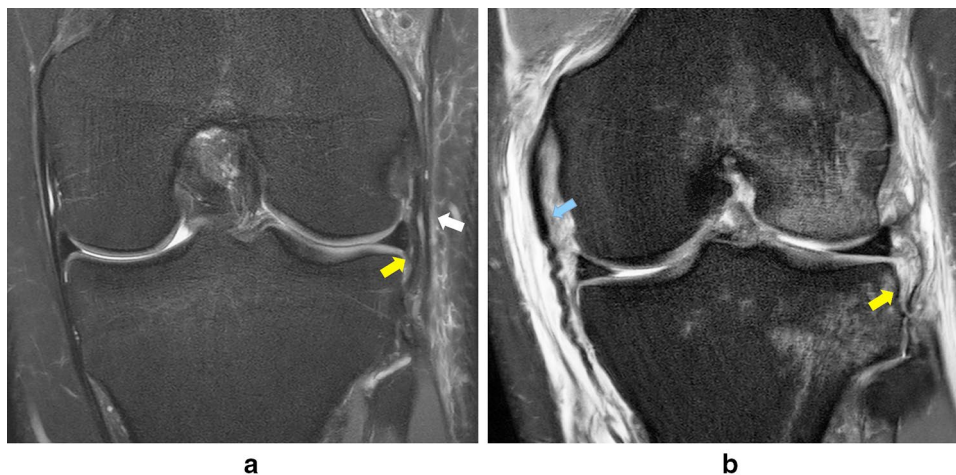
a A coronal MRI of a patient with an intact ALL (yellow arrow). The LCL is demonstrated with a white arrow. According to Patel et al. [21], the origin of the ALL was identified in the coronal and axial planes just anterior and distal to the lateral collateral ligament and the ALL bifurcation to its tibial and meniscal insertions, medial to the lateral geniculate artery. The ALL follows an antero-inferior direction to its tibial insertion at approximately 5 mm distal
